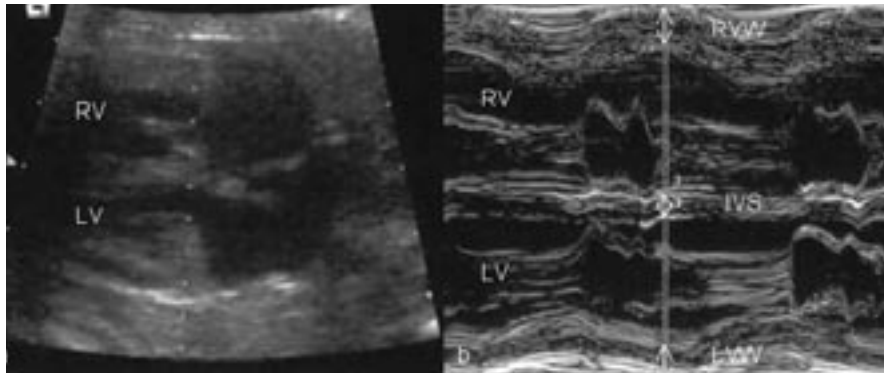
Sonographic image of the fetal heart (a) and the orientation of the M-mode cursor, placed perpendicular to the interventricular septum, just below the tips of the atrioventricular valves. M-Mode measurement (b) in diastole of the left and the right ventricular walls and the septum.
